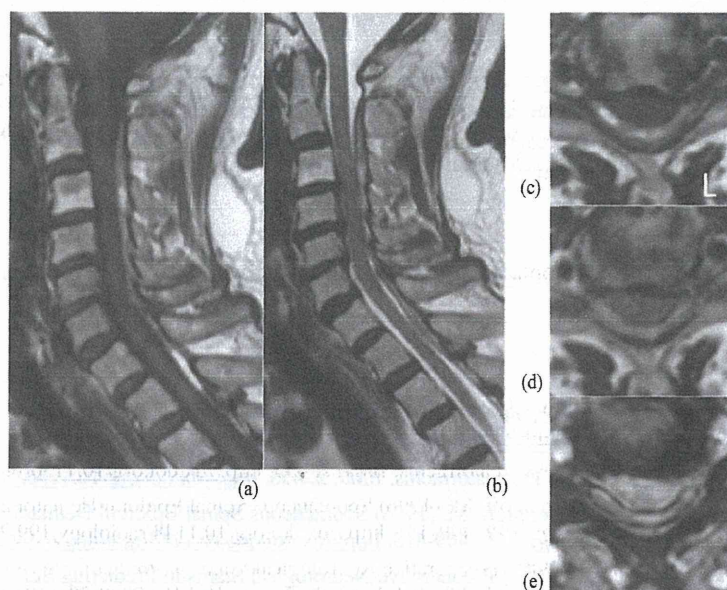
(a) (c) The lesion was becoming thin and revealed hyperintensity on T1WI and mixed intensity on T2WI (b) (d), T2* MRI (e).
